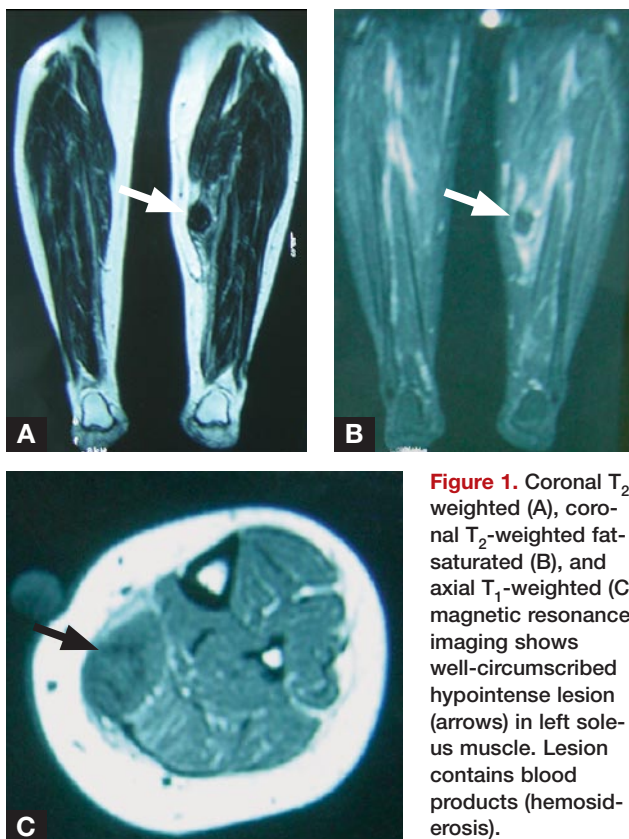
Coronal T_2 -weighted (A), coronal T_2 -weighted fat-saturated (B), and axial T_1 -weighted (C) magnetic resonance imaging shows well-circumscribed hypointense lesion (arrows) in left soleus muscle. Lesion contains blood products (hemosiderin).
